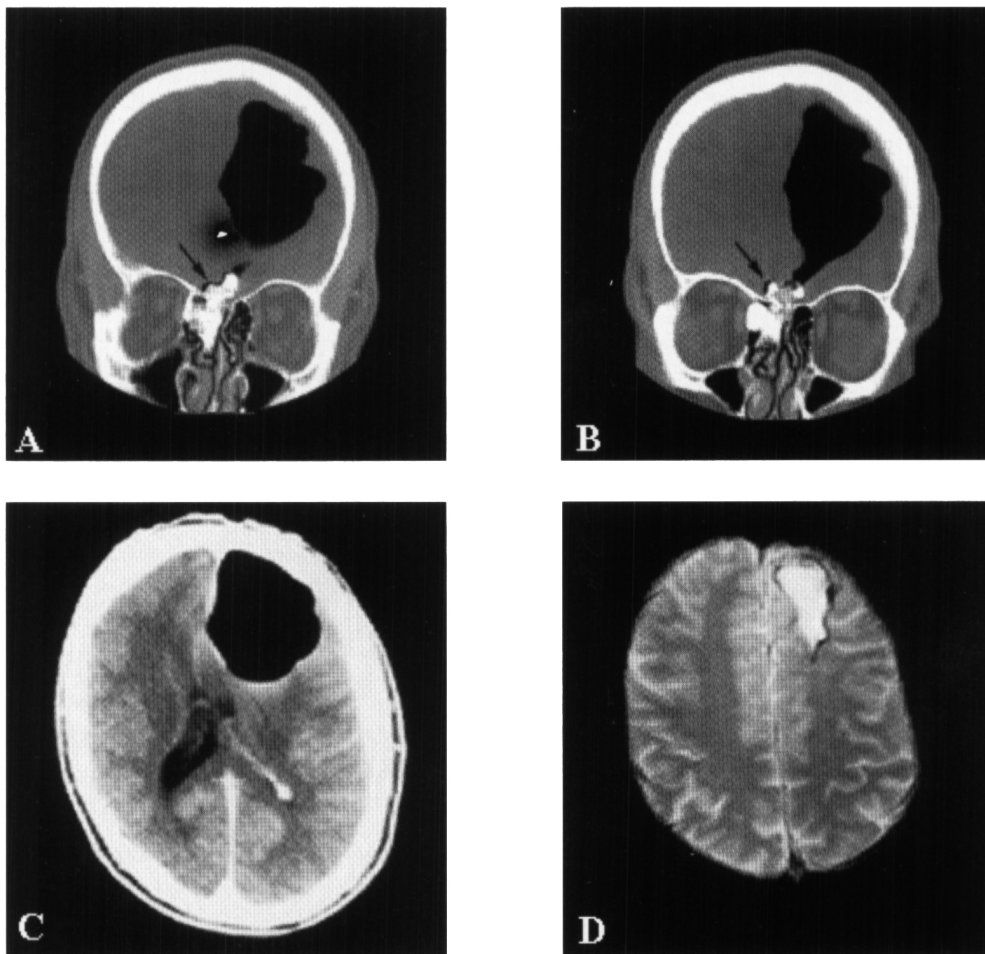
A+B) Coronal images demonstrates the osteoma in right frontal-ethmoid sinus (arrows) with intracranial extension to the left of midline contiguous with the intracranial air. C) Axial non-contrast CT head at presentation showing tension pneumocephalus with displacement of left frontal lobe. D) T2-weighted MR axial image demonstrating left frontal encephalomalacia at 2½ years follow up.
